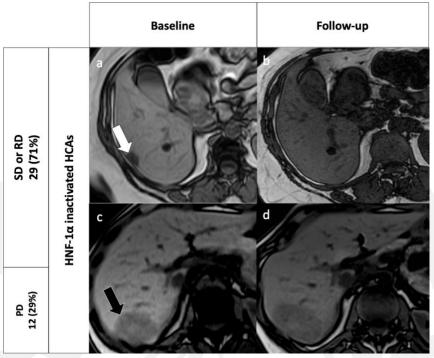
Representative images of size changes of HNF-1α inactivated hepatocellular adenomas. Outcome of patients with only HNF-1α inactivated hepatocellular adenomas in our study is also represented in number and percentages on the left. Top row: 47-year old woman with hepatocellular adenomas; axial contrast-enhanced MRI images at baseline (a) and at 12-year follow-up (b) demonstrate a complete regression of an HNF-1α inactivated hepatocellular adenoma (white arrow). Bottom row: 42-year old woman with hepatocellular adenomas; axial contrast-enhanced MRI images at baseline (c) and at 5-year follow-up (d) demonstrate a substantial progression of an HNF-1α inactivated hepatocellular adenoma (yellow arrows).
